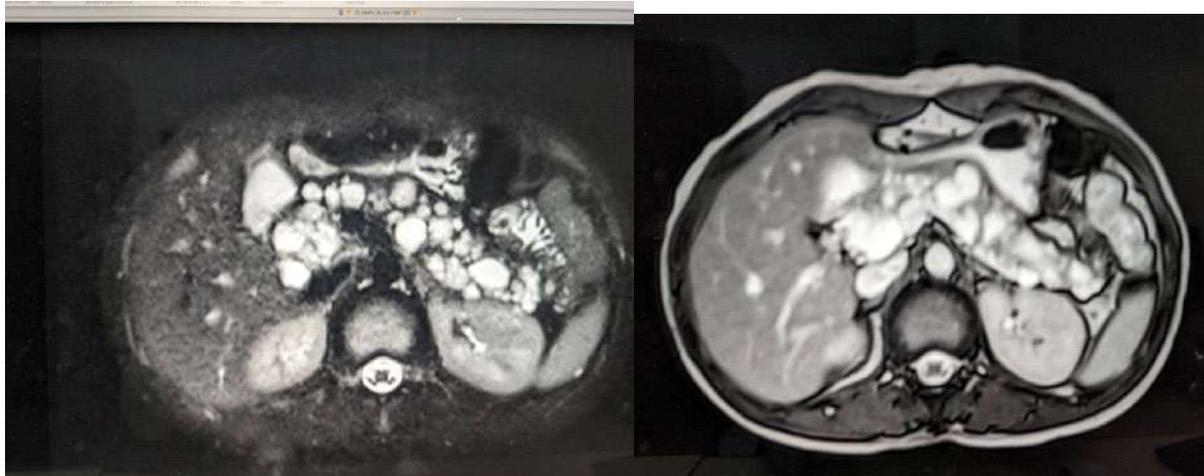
Magnetic resonance imaging of abdomen T2 weighted image and T2 fat sat images showing multiple well defined rounded variable sized thin-walled hyper intense lesions are seen in the head, body, and tail of the pancreas.
